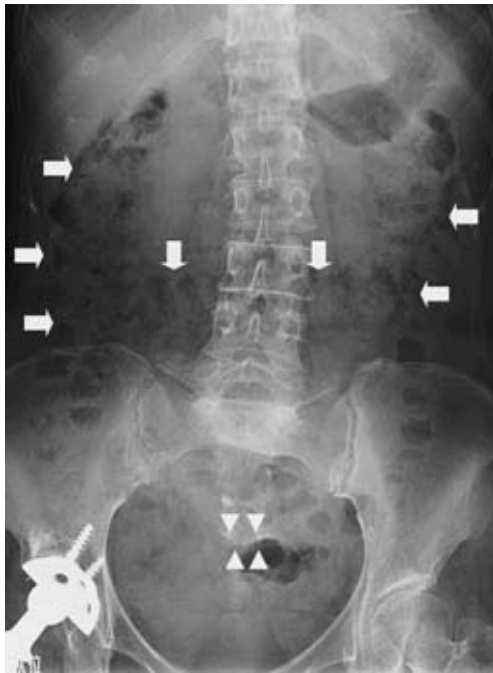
A plain abdominal X-ray film shows feces blockage in the ascending, transverse and descending colon (arrows). Staples of the rectal anastomosis are shown (arrowheads).
